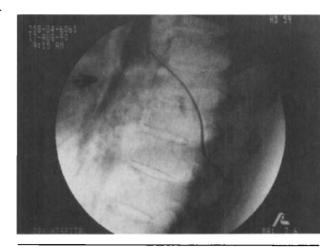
FIGURE Intraoperative radiograph showing interpleural catheter. Arrow points to radioopaque column of dye in the right paravertebral gutter.
